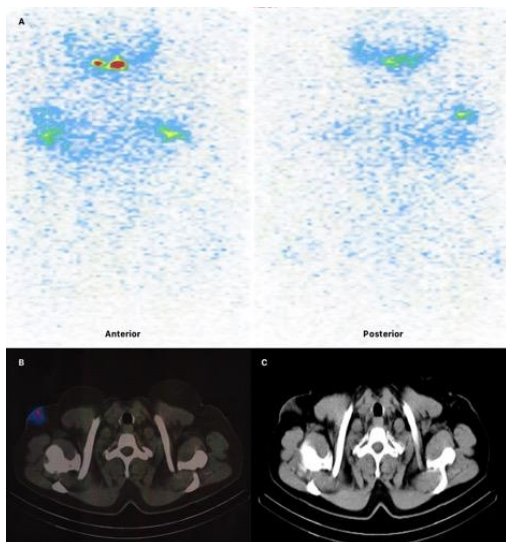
Ectopic axillary breast tissue. (A) planar scintigraphy. (B) SPECT/CT. (C) CT. Images revealed tracer uptake in the right axilla (A-C).
